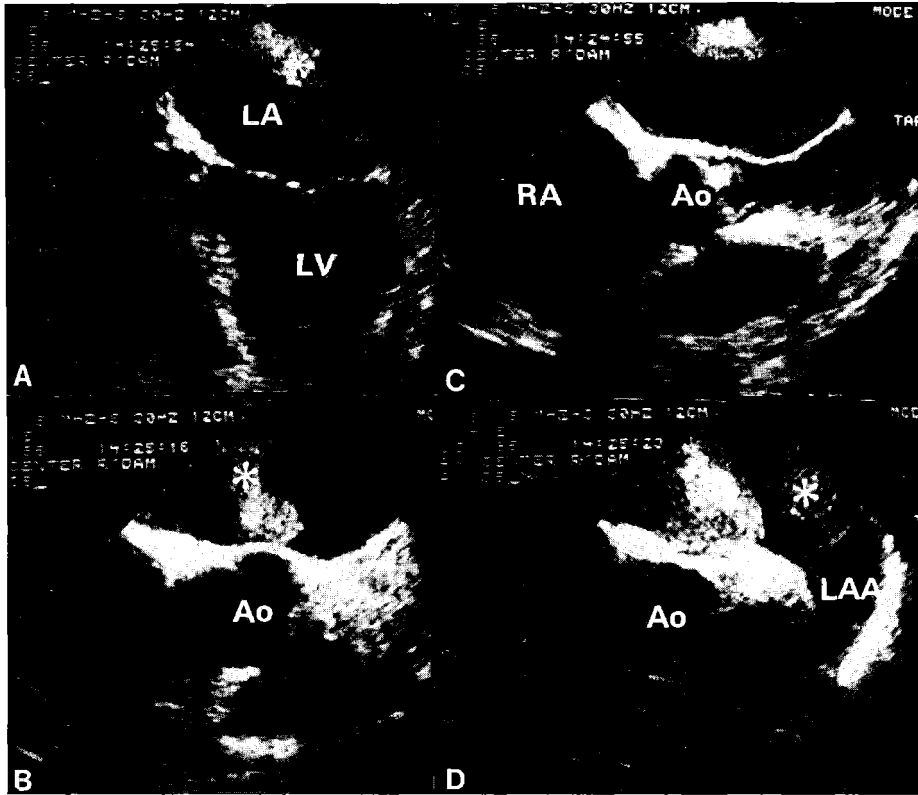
Esophageal echocardiograms (A-D) obtained in a patient with mitral valve stenosis and a history of transient ischemic attacks. A large mass lesion (asterisk) was attached to the left atrium (LA) posterior and superior wall. Note the extension of this mass in different cross-sections. The left atrial appendage (LAA) remained free from the mass. Ao = aorta; RA = right atrium; LV = left ventricle.
